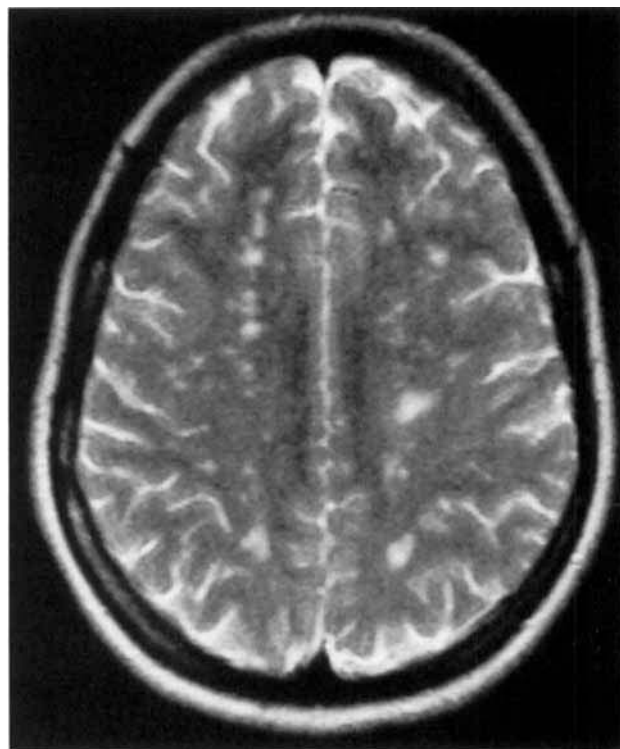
Cranial MRI of a 39-year-old woman showing extensive white matter hyperintensities on T2WI. This woman has had at the age of 33 one transient episode of blurred vision of the left eye lasting 24 hours. Six months later she had a transient episode of dysphasia lasting 2 hours. At the age of 34 she has had a right hemiparesis lasting 1 month. She suffers migraine with aura since the age of 36. Immunologic, hematologic and cardio-vascular investigations were normal. CSF examination showed oligoclonal IgG fraction and 5 cells/mm³.
